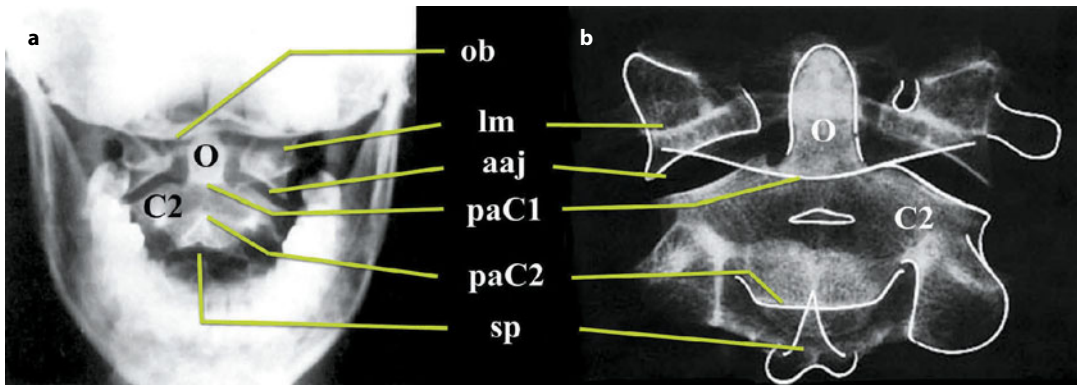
Plain radiograph (anteroposterior projection) of the occipito-vertebral hinge (a) and anatomical preparation of dry bone (b). Odontoid process (dens) (*O*); body of C2 (*C2*); occipital bubble (*b*); lateral mass of C1 (*lm*); atlanto-axial joint (*aaj*); posterior arch of C1 (*inferior edge*); posterior arch of C2 (*superior edge*); spinous process of C2 (*sp*)
